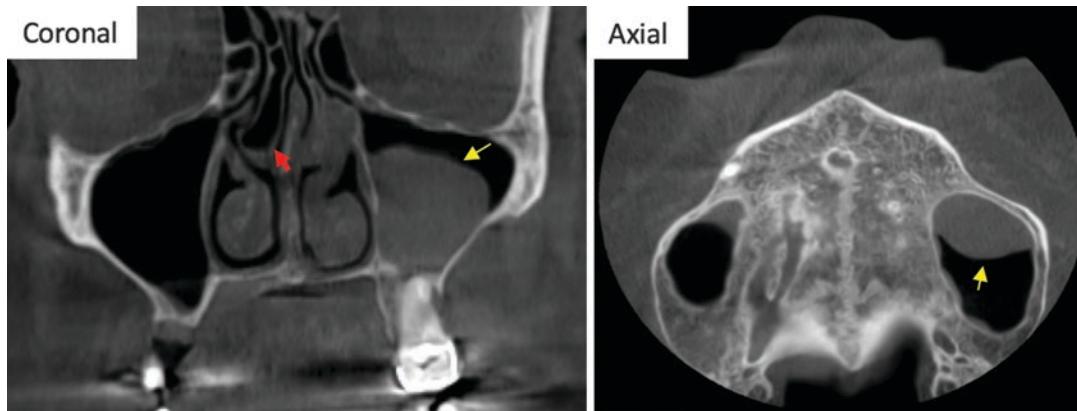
CBCT images show a relatively large homogeneous rounded opacity, possibly a mucus retention pseudocyst, in the left maxillary sinus (yellow arrows). Concha
